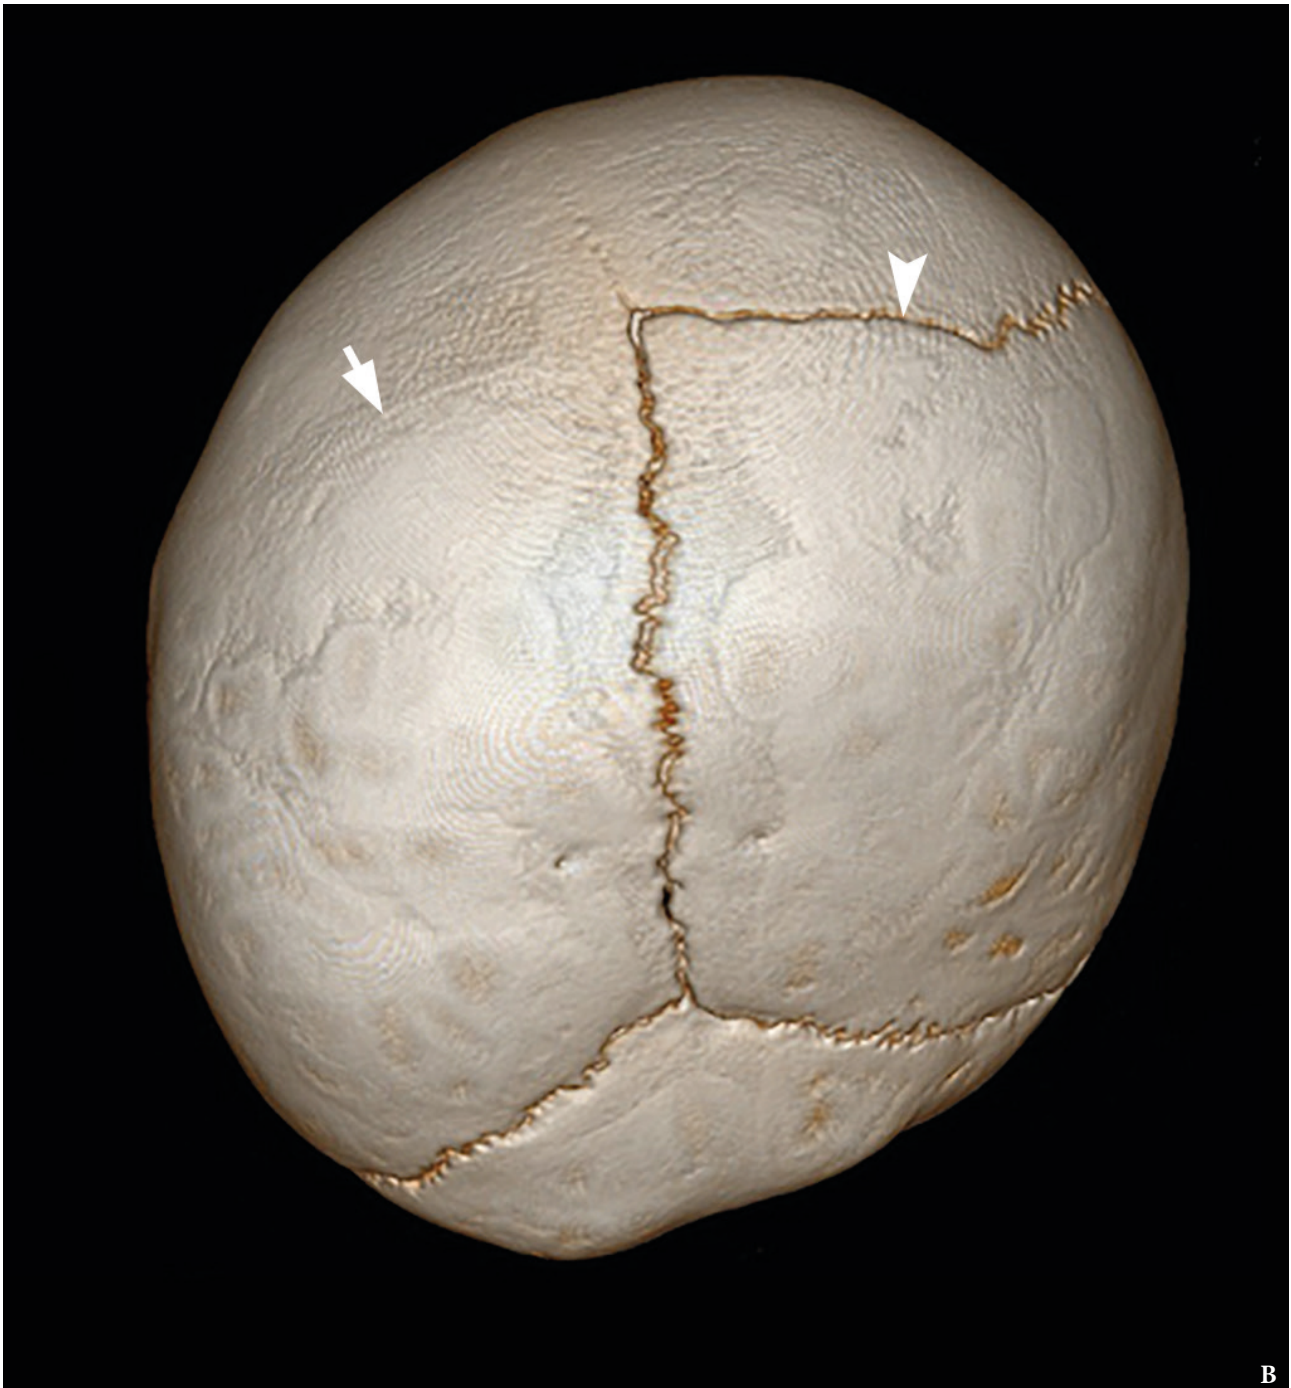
(cont'd). Superior view (B) of 3D-CT volume-rendered image of a 7-month-old boy with anterior plagiocephaly as a result of left coronal suture fusion (*arrow*) which leads in flattening of the frontal bone on the affected side, and prominent frontal bossing to the contralateral side. There is also evident orbit asymmetry. The right coronal suture is still open (*arrowhead*). (Fig 3 continued on next page.)
